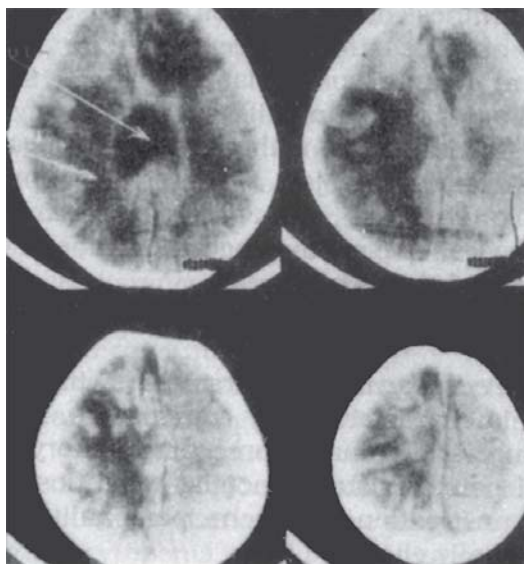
CT scan showing multiple cerebral abscesses in an infant suffering from suppurative otitis media (SOM).
